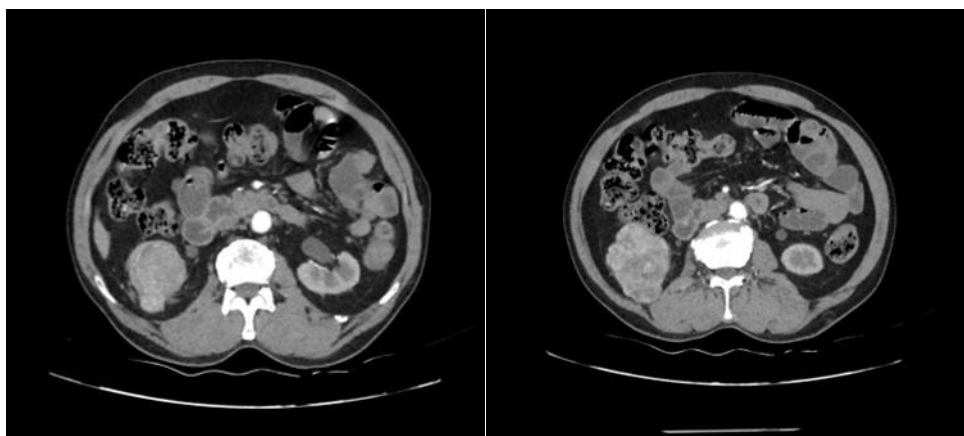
Patient radiographic evaluation.
